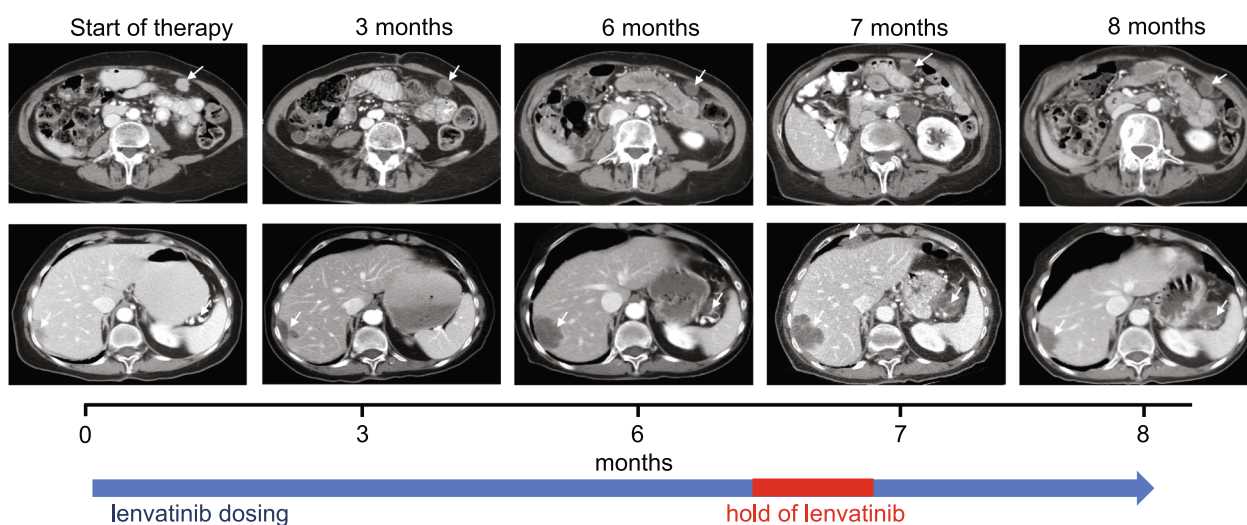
Course of lenvatinib/pembrolizumab therapy for case 1. Representative computed tomography images for longitudinal disease monitoring. Arrows point to representative disease sites.
